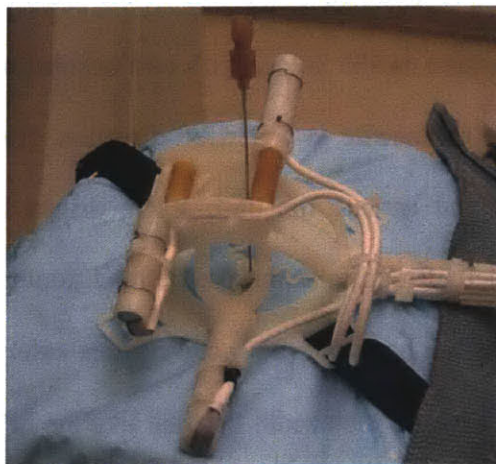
Robopsy has a small footage and can actively rely the angle required for the device from the medical image software. This device is CT compatible and can place a single probe [12].
